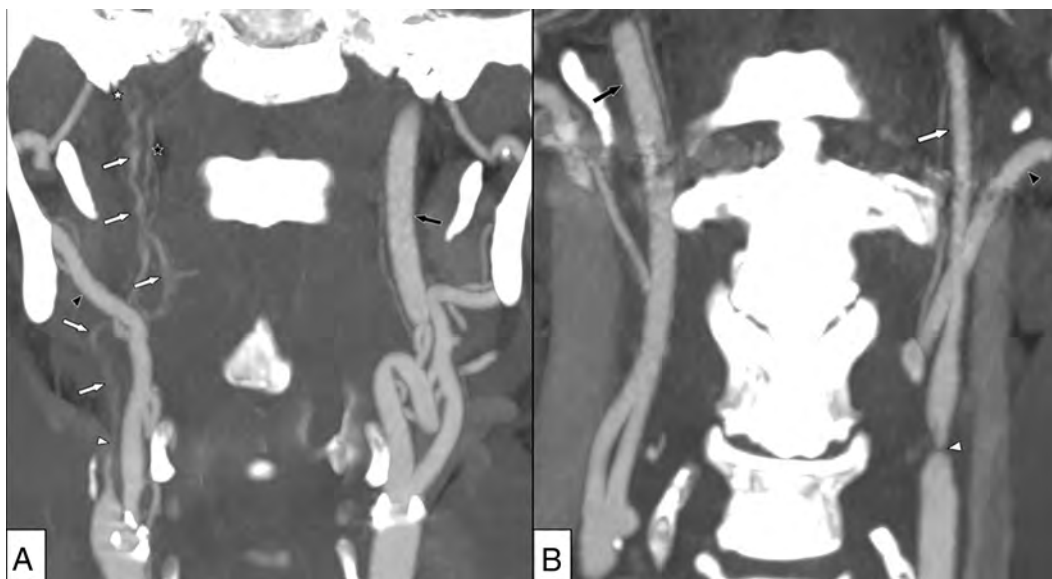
A, Right-sided near-occlusion with full collapse. Coronal view of CTA. Beyond severe stenosis (white arrowhead), distal ICA is difficult to visualize and has a threadlike appearance (white arrows). The distal ICA is clearly smaller than both the contralateral ICA (black arrow) and ipsilateral external carotid artery (black arrowhead) but is similar to the ascending pharyngeal artery (black star). A thrombus just proximal to the skull base is suspected (white star). ICA flow was 6 mL/min on the right side and 267 mL/min on the left side. B, Left-sided near-occlusion without full collapse. Coronal view of CTA. After severe stenosis (white arrowhead), the distal ICA is small but normal-appearing (white arrow), smaller than the contralateral ICA (black arrow), and similar to the ipsilateral external carotid artery (black arrowhead). ICA flow was 37 mL/min on the left side and 259 mL/min on the right side.
